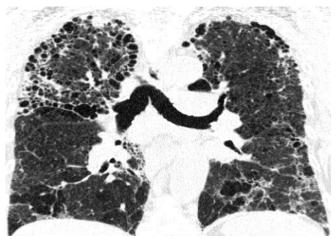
CT Findings suggestive of Chronic Hypersensitivity Pneumonitis
